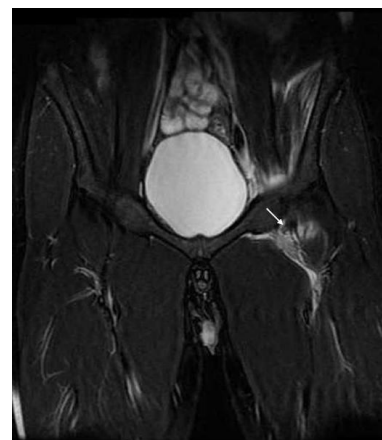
STIR coronal hips MRI at level of pubic symphysis at level of the 4 mm behind from Figure 3. The partial tear of the left psoas major tendon is visualized (white arrow). High signal intensity hematoma is along the left psoas major tendon.
